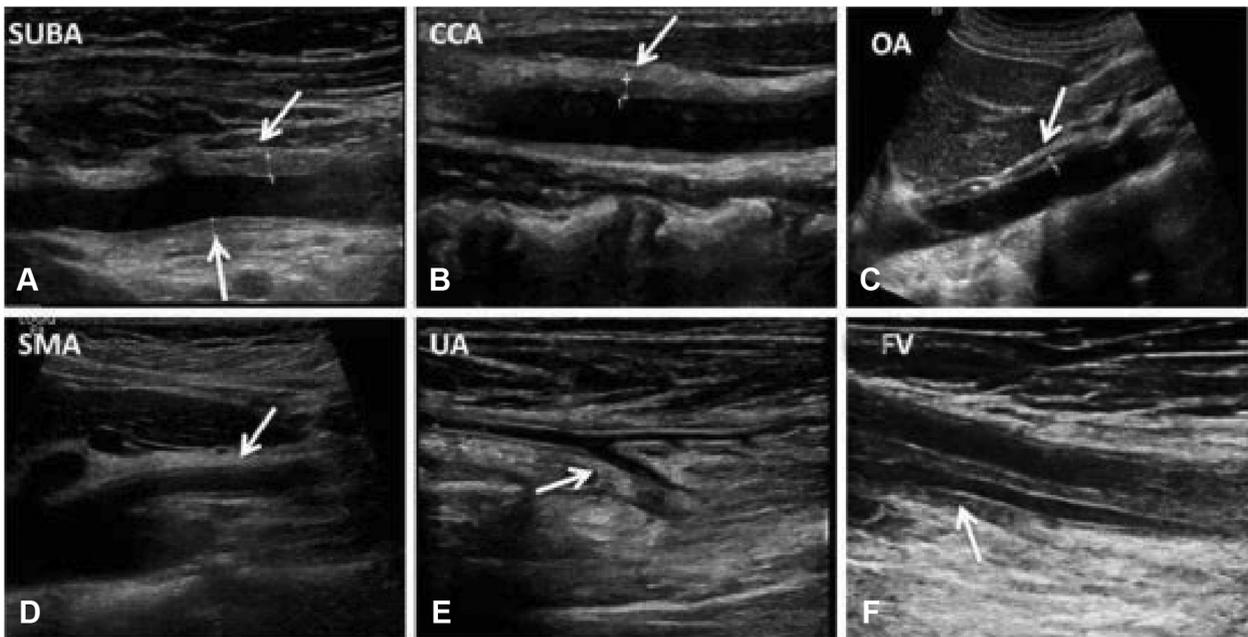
Vascular lesions on longitudinal ultrasound image. Diffuse thickening of arterial wall and stenosis of the lumen. A, The wall thickness of the subclavian artery (*SUBA*) was 2.2 mm. B, The wall thickness of the common carotid artery (*CCA*) was 1.45 mm. C, The wall thickness of the upper segment abdominal aorta (*OA*) was 3.3 mm. D, The wall thickness of the superior mesenteric artery (*SMA*) was 1.8 mm. E, The wall thickness of the ulnar artery (*UA*) was 1.1 mm. F, Thickening of the wall of the deep veins in the lower limbs. The wall thickness of the femoral vein (*FV*) was significantly increased (1.9 mm).
